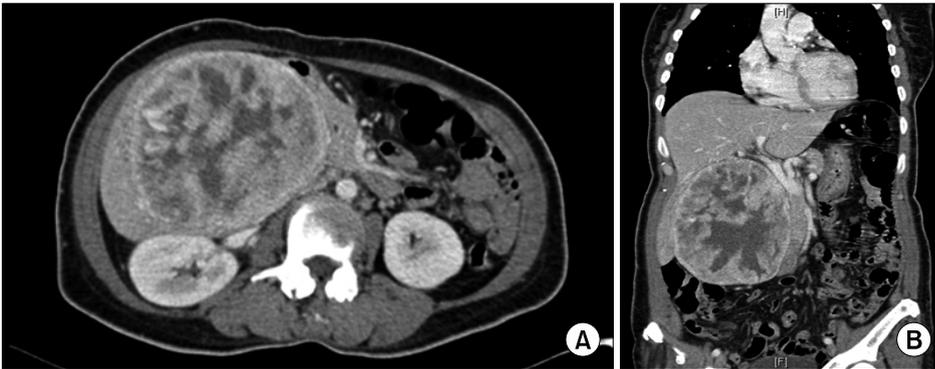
Computed tomography scan of the hepatic mass: Axial (A) and coronal sections (B).
